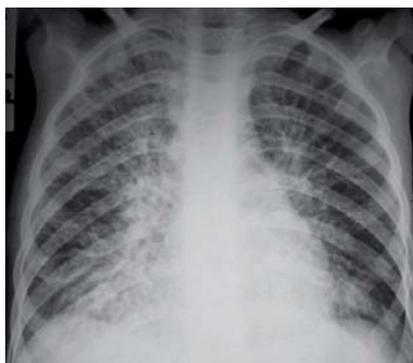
Chest radiograph of the same patient, showing Kerley's B-lines – short horizontal lines at the lung periphery, caused by interlobular septal thickening.
